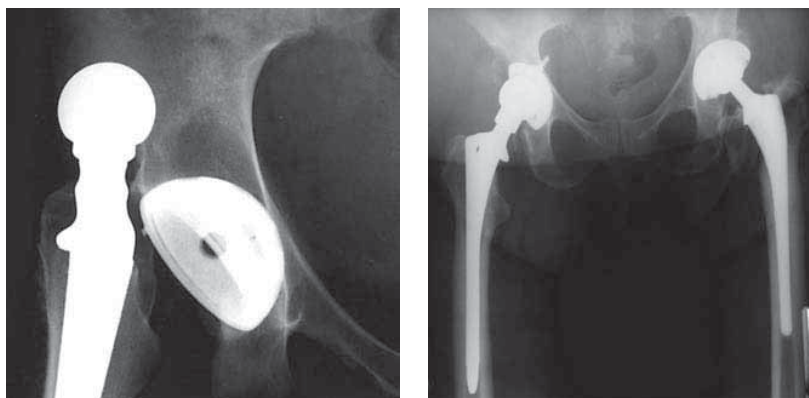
Close scrutiny of the radiographs of a dislocated total hip replacement may be very useful. The retroverted femoral component seen on this radiograph (and confirmed intraoperatively) was the cause of recurrent dislocation in this patient.
